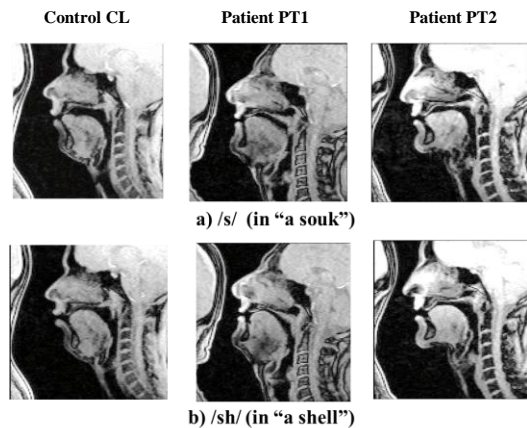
Mid-sagittal MR images of /s/ and /sh/ for the three subjects. A) /s/ in “a souk”, B) /sh/ in “a shell”
